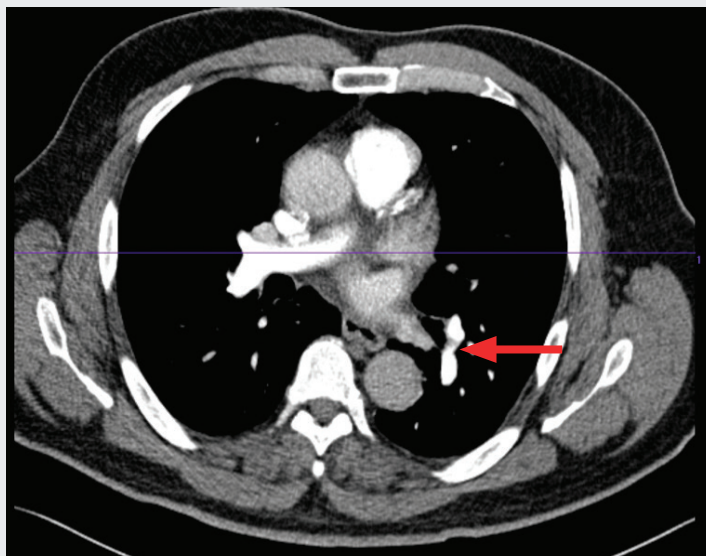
Enhanced axial view of the CT chest showing small filling defect in the sub segmental branches of the left lower lobe (arrow).
